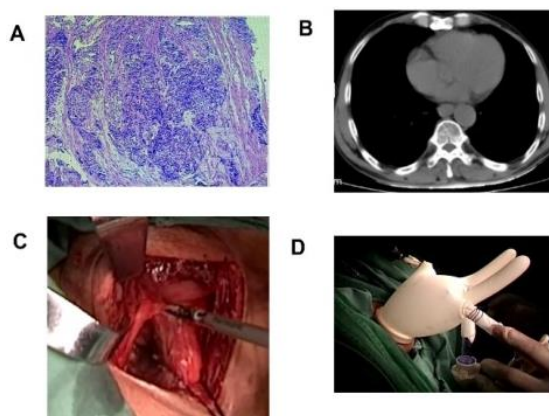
Biopsy results confirmed esophageal squamous cell carcinoma, with a CT scan staging of T3N0M0, as shown in [Figure 2A](#) and [B](#). A 4 cm incision was made at the anterior edge of the left sternocleidomastoid muscle, and the cervical esophagus was mobilized, as shown in [Figure 2C](#). The protective sleeve was inserted, as shown in [Figure 2D](#).
